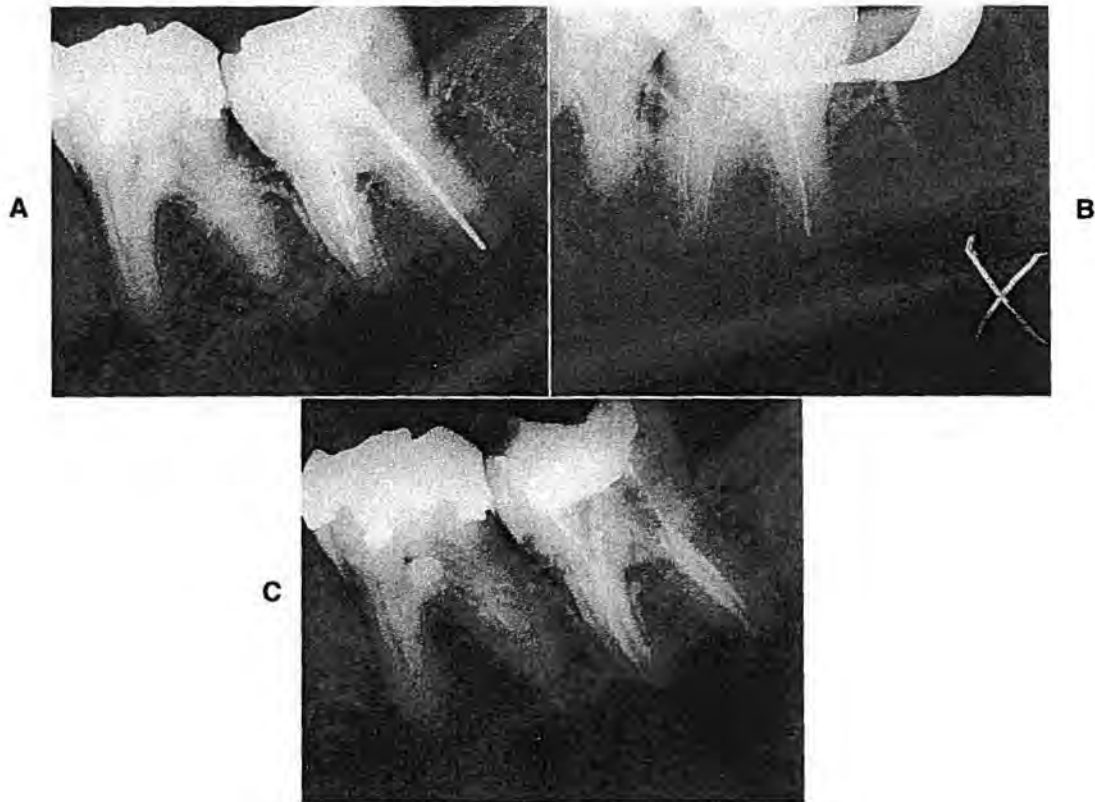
Bypassing ledged canal by precurving files. A, Preoperative radiograph of mandibular second molar, 1 year after treatment with silver points. The tooth was tender to percussion, and the periodontal ligament space is thickened on the mesial root. Note that the fillings in the mesial root are very straight, even though the canals appear to be curved. B, The silver points were removed. If straight files were placed into the mesial canals, there would be no way to bypass the ledges. However, by sharply precurving the files, as shown in Figure 5-16, A, the correct position to terminate preparation was reached, according to this radiograph taken from the distal. A second distal canal was also located. C, Final filling of four canals with laterally condensed gutta-percha completes a successful re-treatment.
